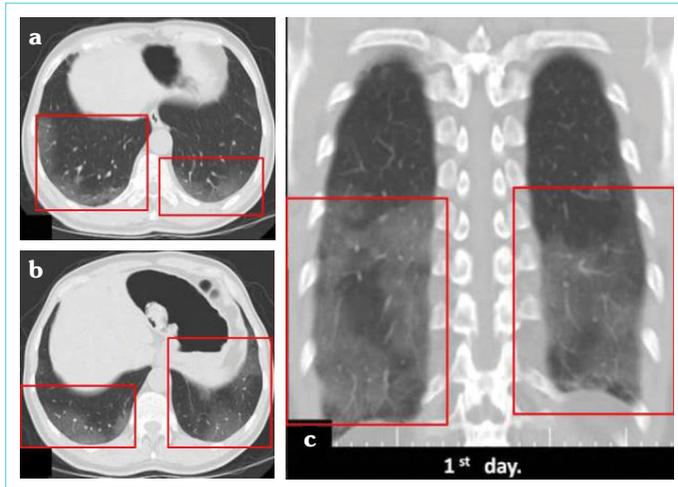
64-year-old man with a positive RT-PCR. Unenhanced thorax CT examination performed at admission. The axial images (a, b) and a coronal reformatted image (c) show bilateral opacities of ground-glass density with a tendency to coalesce and concomitant vascular dilation, especially at posterior and lateral segments of lower lobes (red frames). These CT signs are compatible with stage 1 COVID-19 pneumonia
